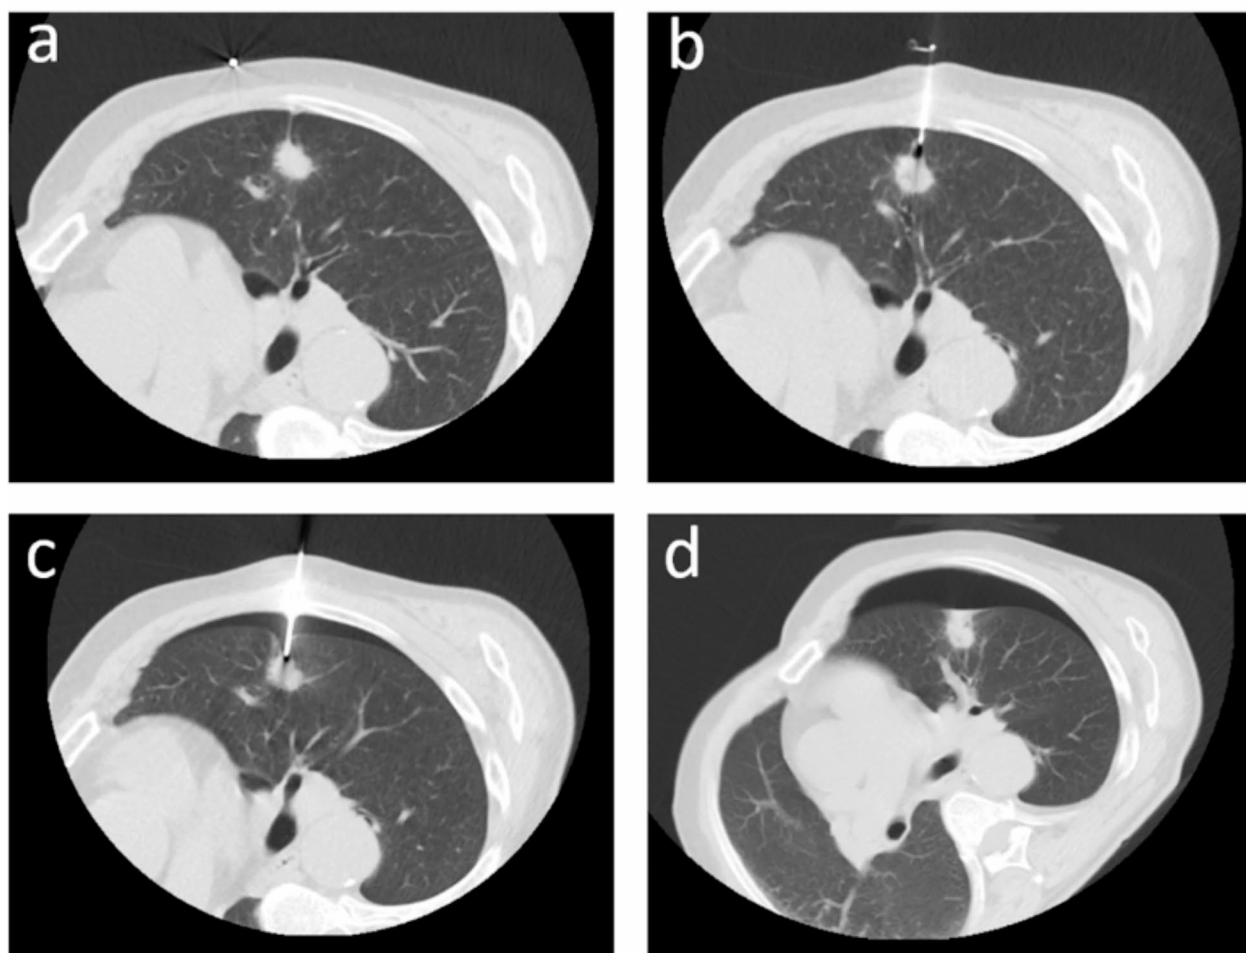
A PTNB procedure on a nodule with PTS in a 63-year-old male patient. (a) A chest CT image shows a nodule with PTS in the left upper lobe. (b-c) Our puncture path passed through the linear tags and the pleura affected by the PTS. (d) Postoperative CT revealed pneumothorax in the left thoracic cavity
